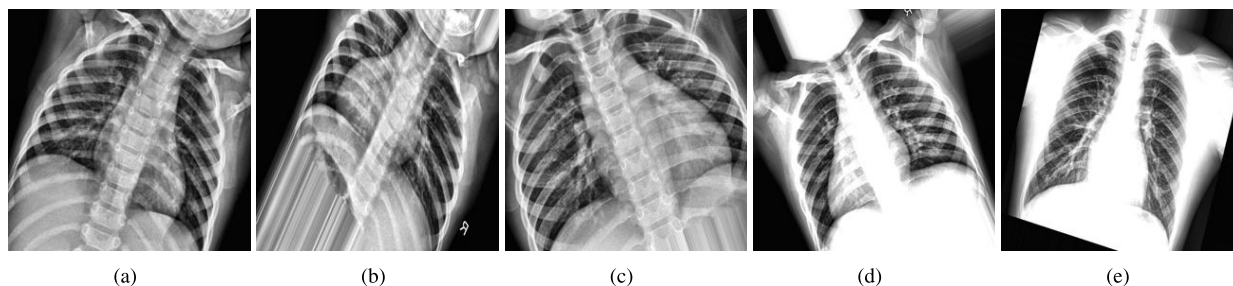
X-Ray Images of (a) Normal (b) CLAHE enhanced image of Normal sample (c) Pneumonia (d) CLAHE enhanced image of Pneumonia.
